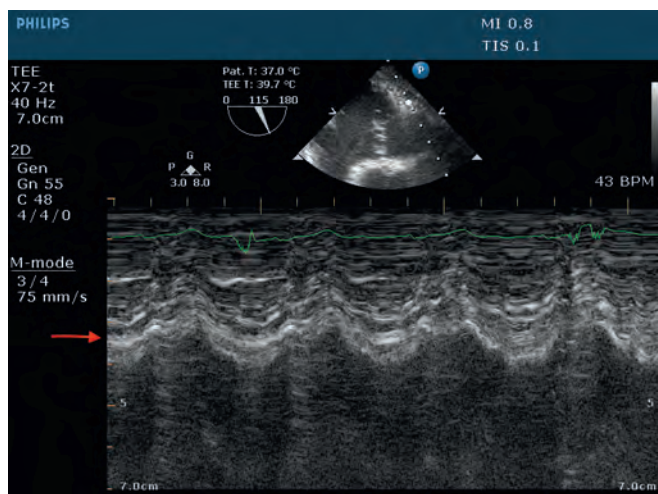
An example of tricuspid annular plane excursion using M-mode echocardiography on the tricuspid annulus. The red arrow points to the tricuspid annulus. A visual estimation of the annular movement suggests good right ventricular function. TEE, Transesophageal echocardiography.
